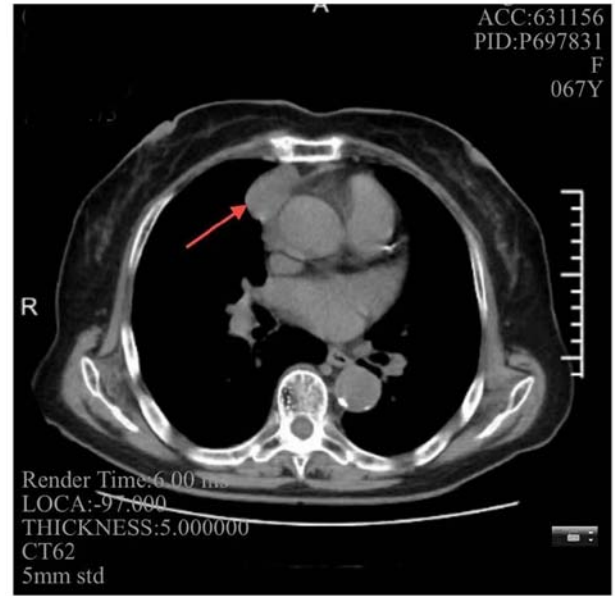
Computed tomography shows a soft tissue shadow ~3.8x2.3 cm in size in the anterior mediastinum with clear boundaries (red arrow).
